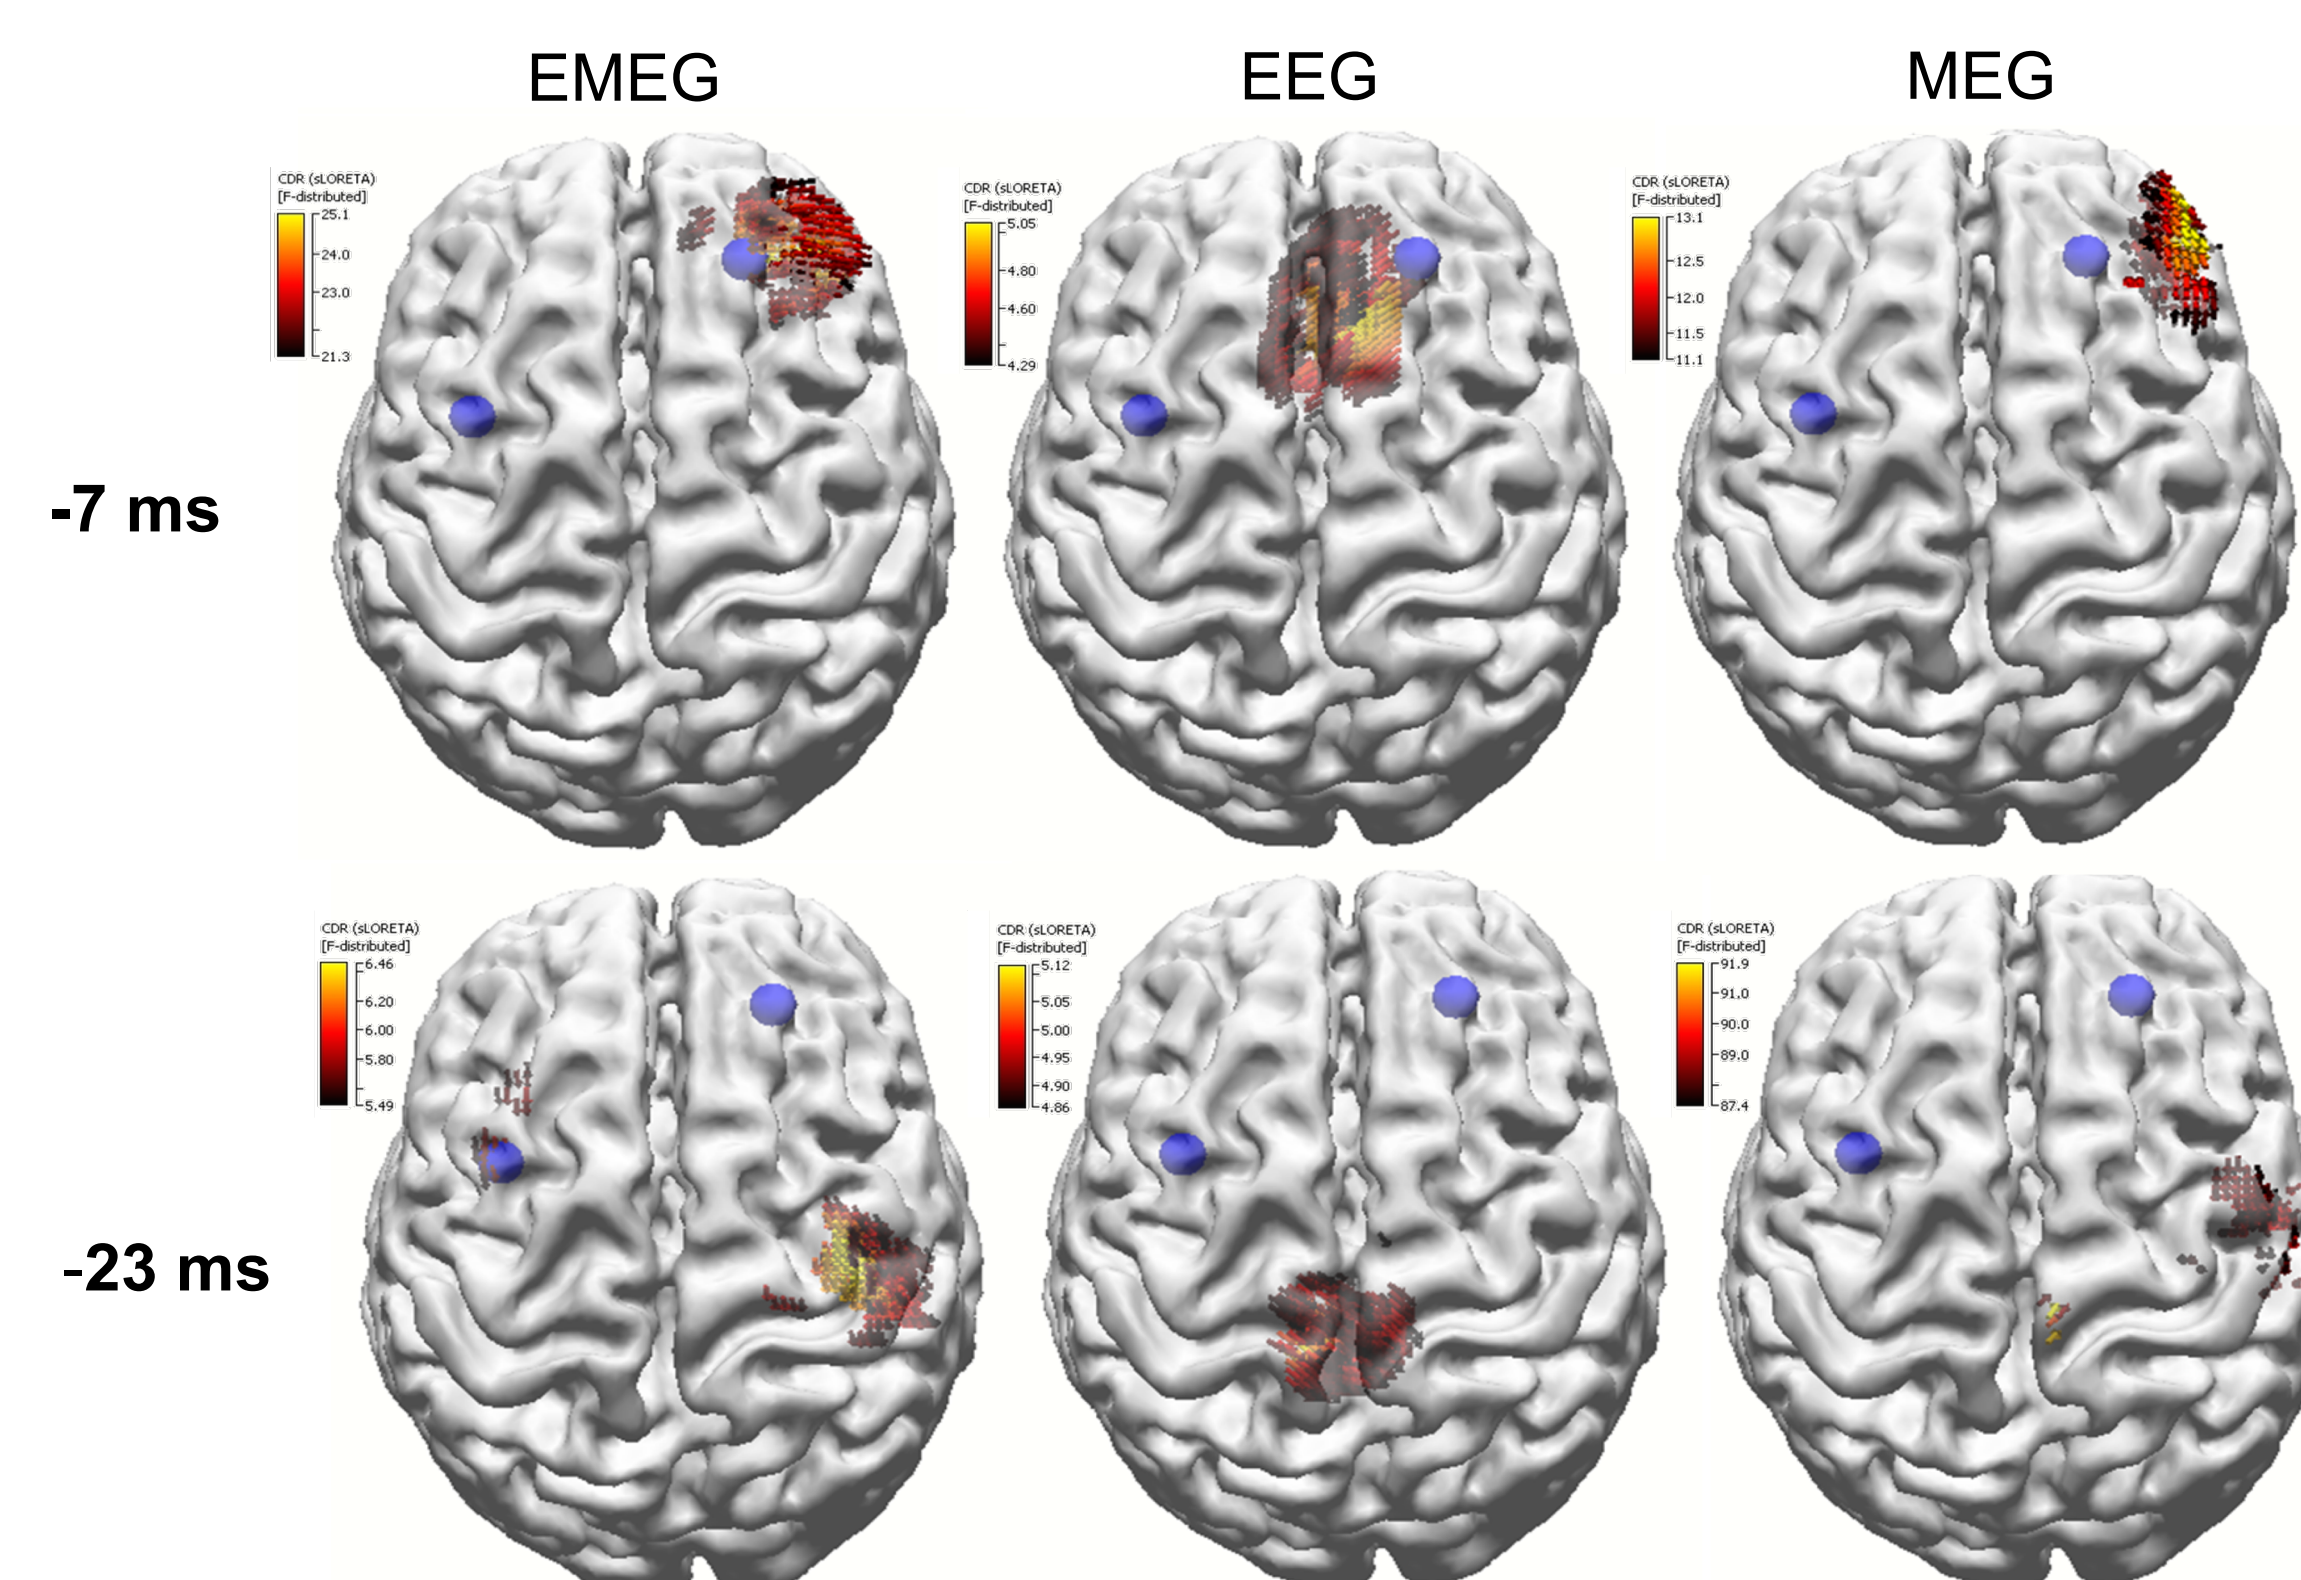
EMEG, EEG only and MEG only source reconstructions at -23 ms and -7 ms. A threshold of 85% of the maximum F-value was used for the results. The FCDs detected with MRI are indicated by the blue spheres.
